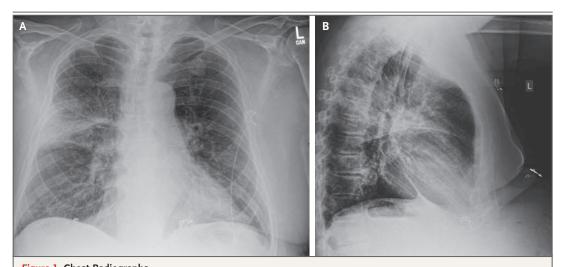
Chest Radiographs. Posteroanterior (Panel A) and lateral (Panel B) views show right upper-lobe infiltrate.
